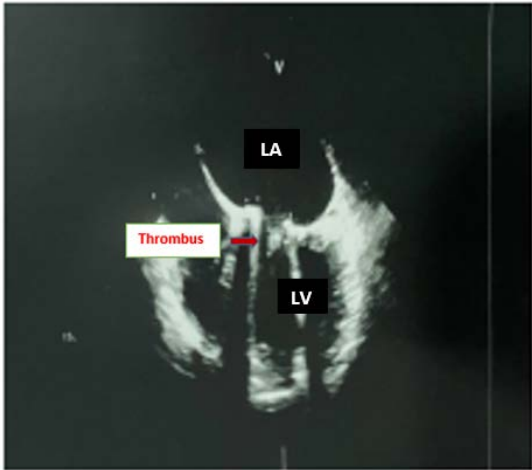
Transesophageal echocardiographic images showing a mobile thrombus attached to the ventricular side of the mechanical mitral valve. LA: Left Atria, LV:Left ventricle
